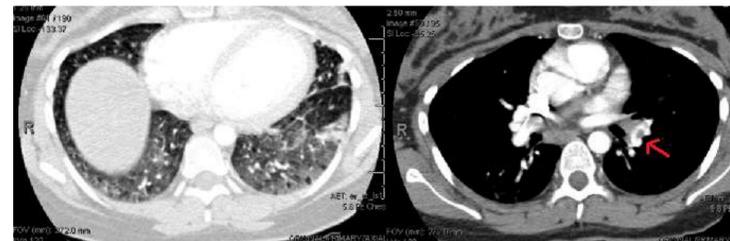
CT chest demonstrating diffuse ground glass opacities (left) throughout both lungs, which can be seen with COVID-19 pneumonia. Acute pulmonary emboli (right) identified in segmental branches of lingula and left inferior lobar pulmonary artery extending into segmental branches of left lower lobe, with filling defect noted by red arrow.
